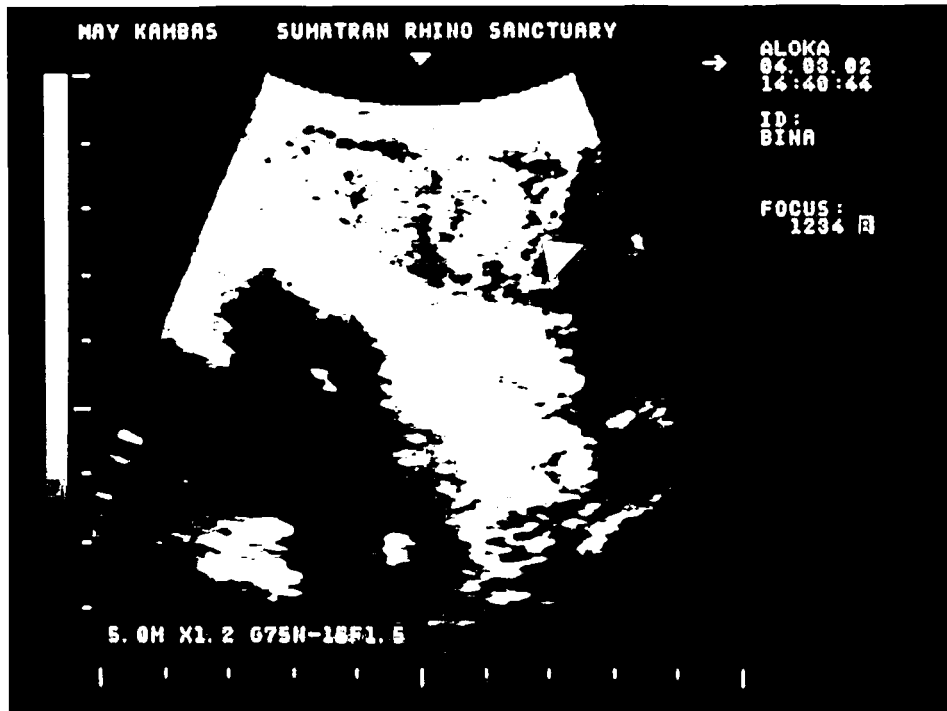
Ultrasound image of two luteal structures (arrows) on Bina's left ovary, indicative of a double ovulation 7 days after breeding by Torgamba.
